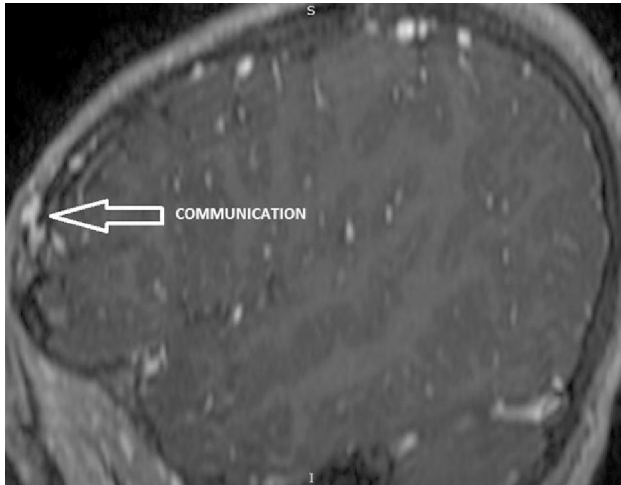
Para-sagittal post-contrast T1-weighted MRI image showing communication between extracranial and intracranial venous channel through a calvarial defect.
